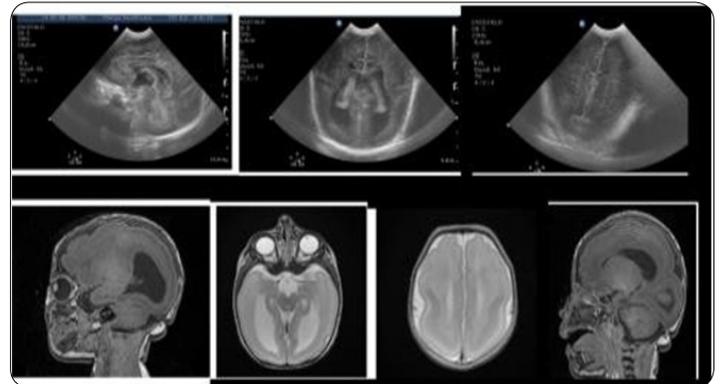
Cerebral ultrasound and Magnetic Resonance at birth: diagnosis of lissencephaly.
